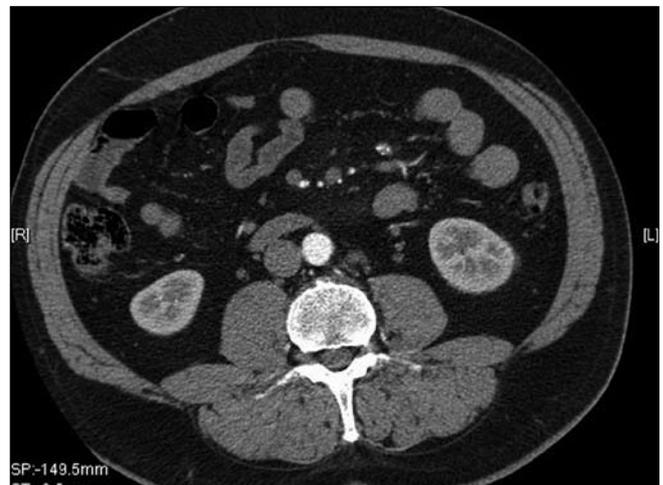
Enlarged retroperitoneal lymph node – CT scan, October 2008.
